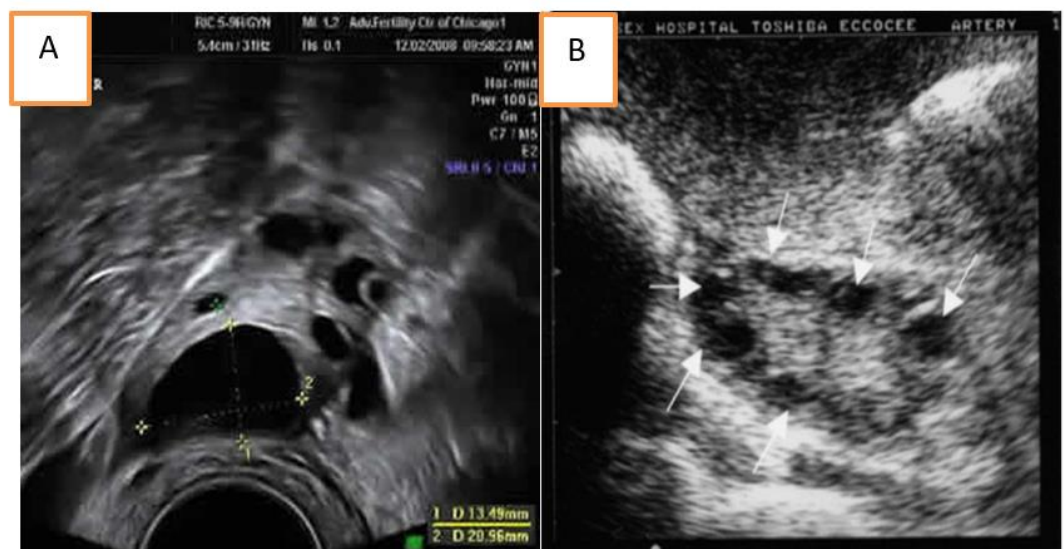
A: An ultrasound image depicting a standard polycystic ovary [6]. B: Ultrasound image depicting a typical ovary [7].
